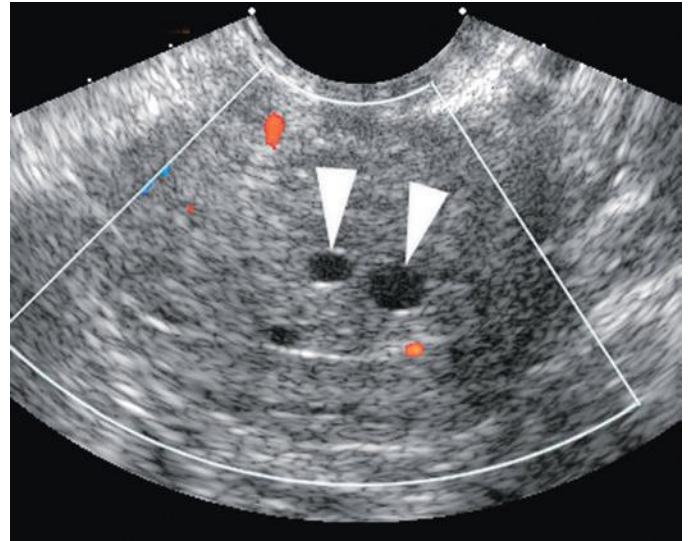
A 57-year-old woman with postmenopausal bleeding and negative endometrial biopsy. Transverse color Doppler image of the uterus shows endometrial thickening with several anechoic internal cysts (*arrowheads*) corresponding to dilated endometrial glands in a polyp. Hysterectomy confirmed a 2-cm endometrial polyp attached to the right uterine cornu. Endometrial biopsy is unreliable for detection of focal endometrial disease, thus making sonographic evaluation an essential part of the workup of postmenopausal bleeding.
